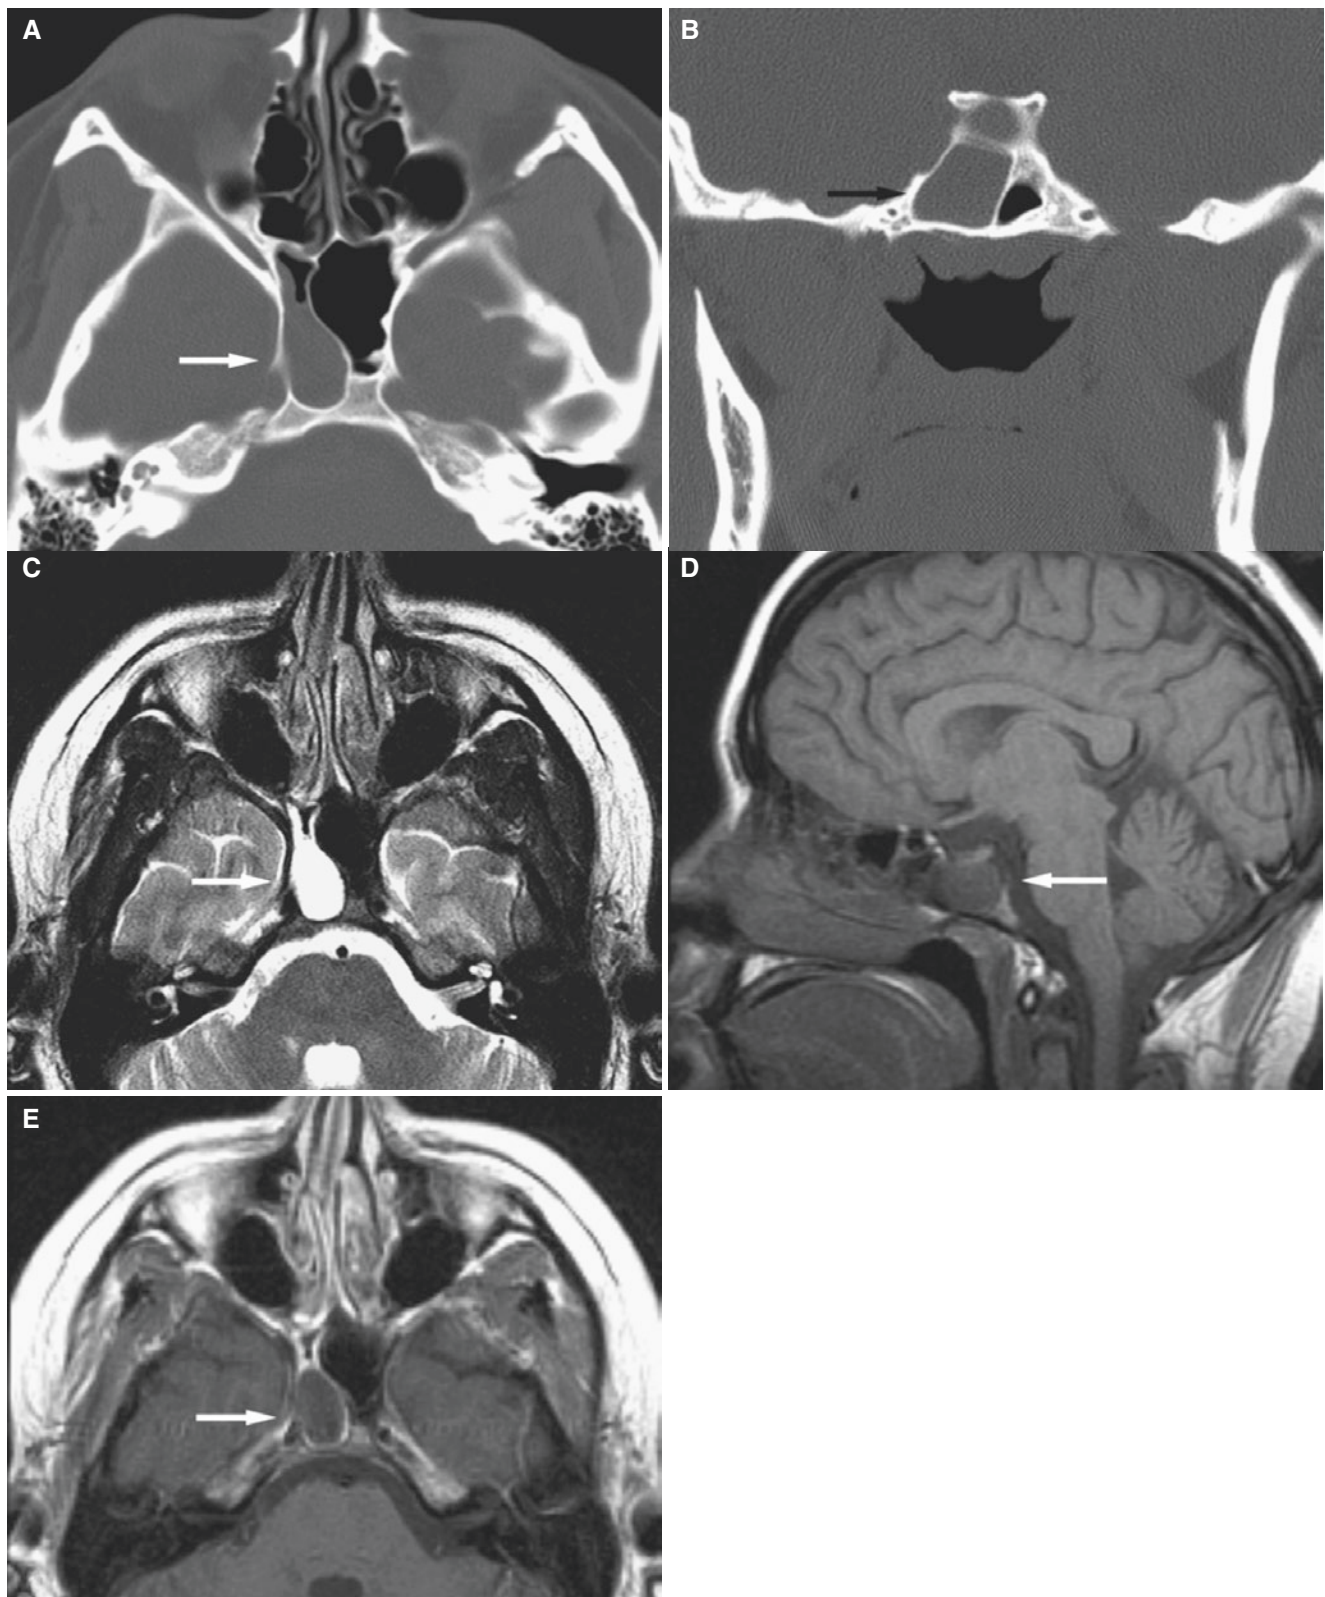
Sphenoid sinus mucocèle; 19-year-old female with past medical history significant for morbid obesity who presented with history of headache for 6 weeks, as well as occasional nausea and vomiting; initially evaluated for suspicion of brain tumor, pseudotumor cerebri, and venous thrombosis. (A) Axial CT image shows expansive mass in the right compartment of sphenoid sinus with intact cortical
